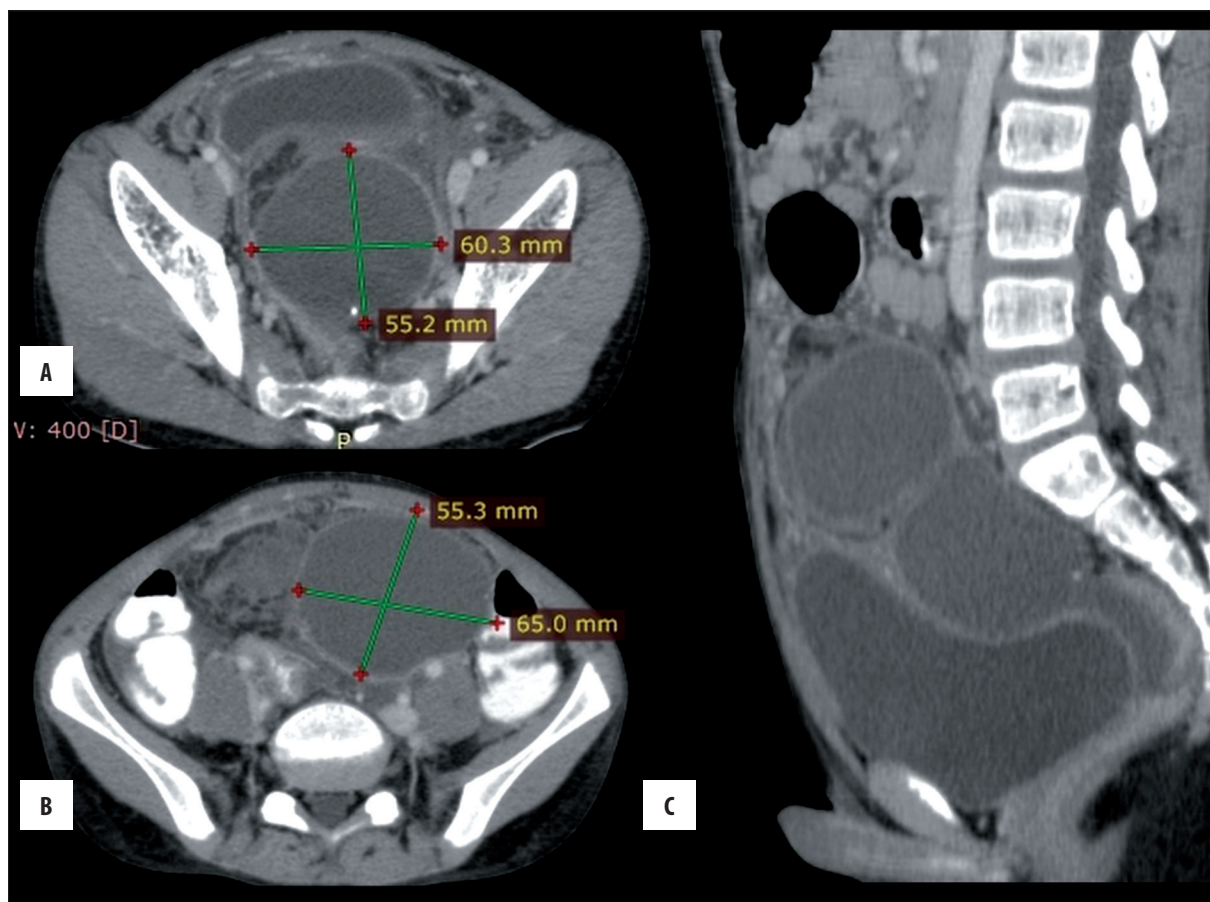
(A, B) Axial and (C) sagittal contrast-enhanced CT images showing two cystic masses in the lower abdomen and pelvis.
